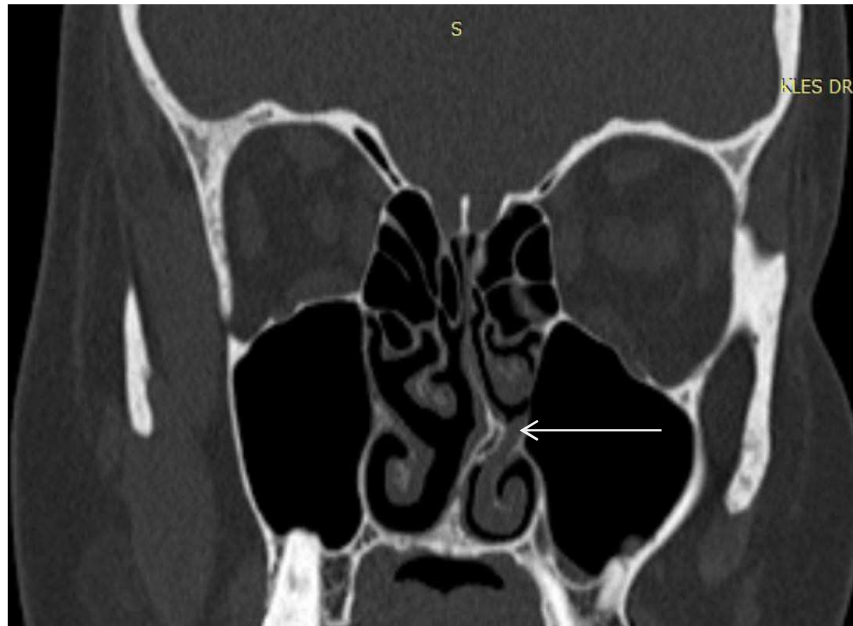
Coronal CT PNS showing Deviated nasal septum with convexity and bony spur towards left side.
